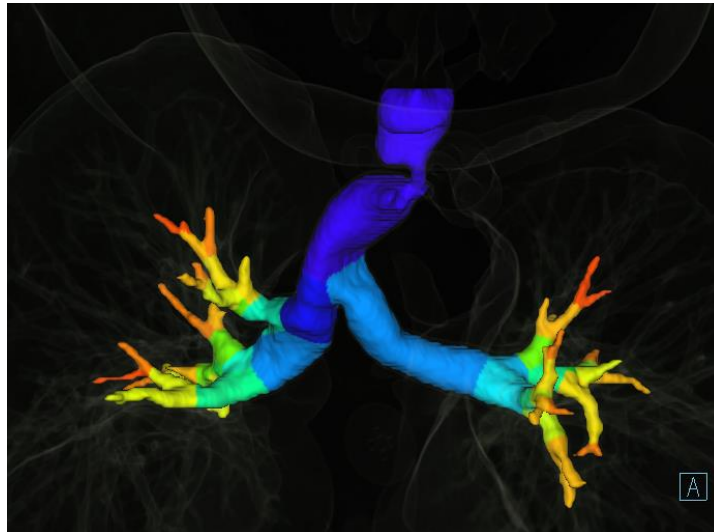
3D reconstruction of the airway tree using images from the computed tomography scan.
